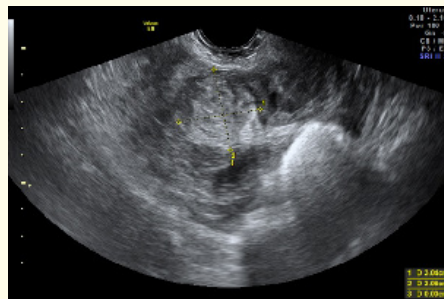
Transvaginal ultrasound image of extraovarian adnexal mass in tubal pregnancy at 6 weeks' gestation.
